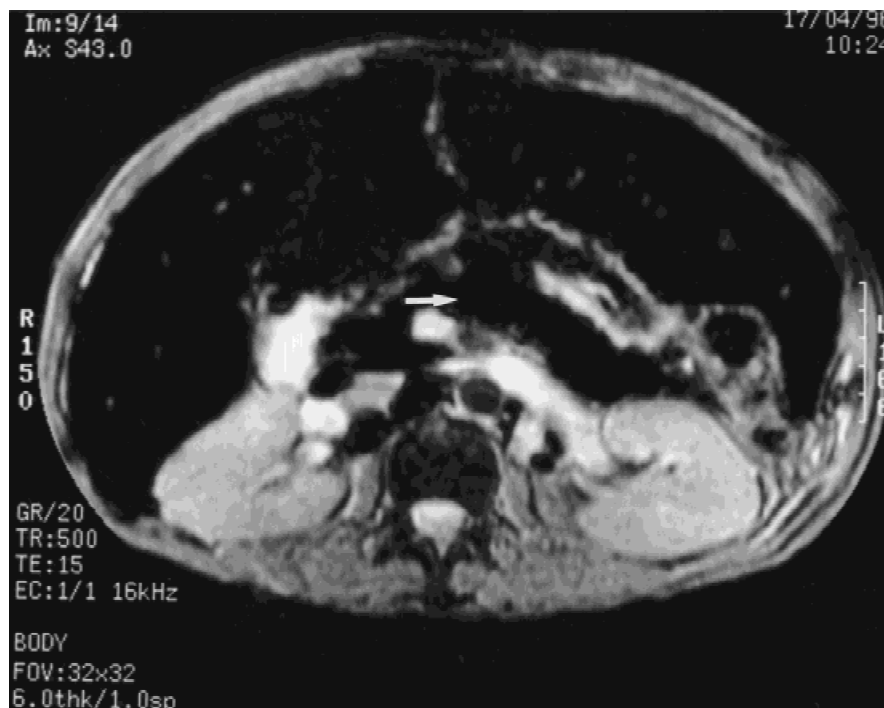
T2* weighted MRI scan film of the abdomen showing generalised decrease in signal intensity in the liver and pancreas (arrow) in keeping with gross iron overload in the liver and pancreas.
